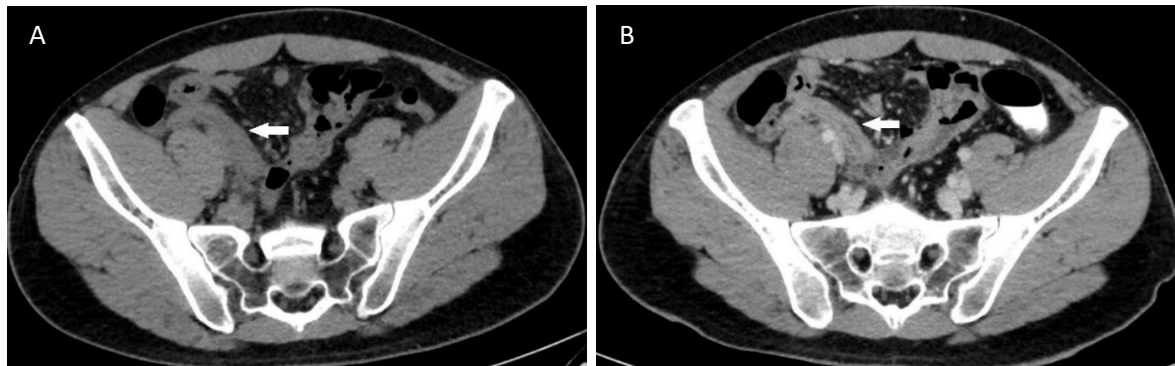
A case that diagnosed acute appendicitis in both unenhanced and IV-contrast enhanced scan in a 29-year-old man presented with migratory right lower quadrant pain. On axial CT image of unenhanced CT (A) showed enlarged fluid-filled appendix with thickened wall (arrow), measuring 1.2 cm in diameter. No intraluminal air is observed. On axial post contrast enhanced CT image (B) showed enlarged fluid-filled appendix with appendiceal wall hyperenhancement (arrow). Periappendiceal fluid and fat stranding are also observed (not shown).
